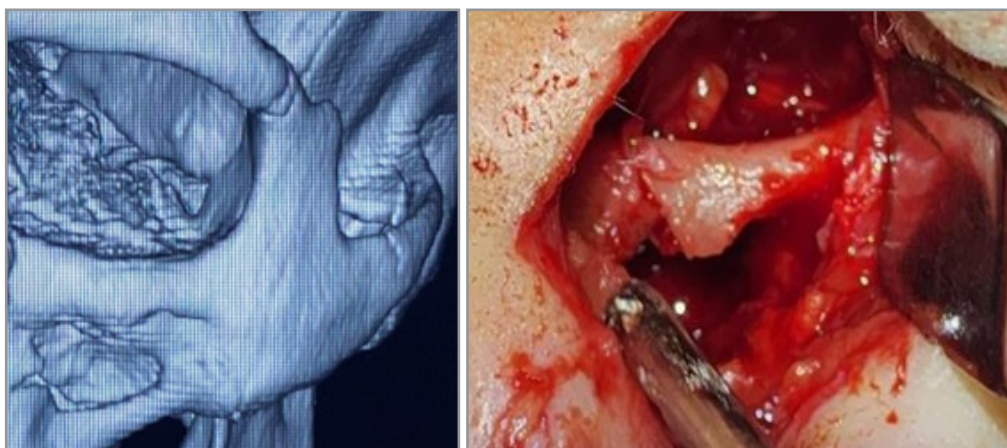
Fracture of the anterior wall of the maxillary sinus (CBCT and surgical observation)
